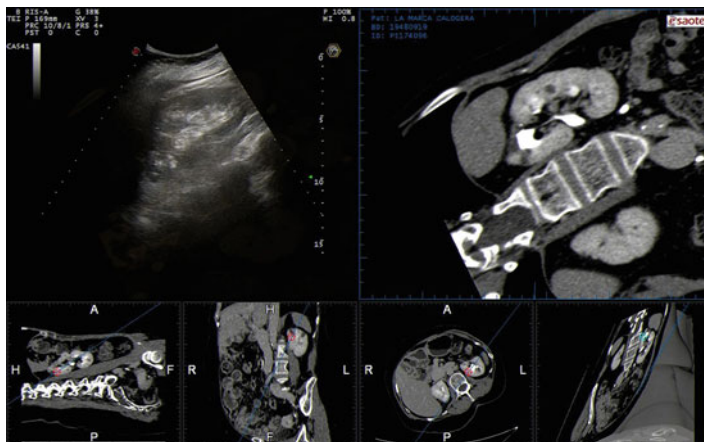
US/CT-guided fusion imaging system for renal percutaneous access guidance
